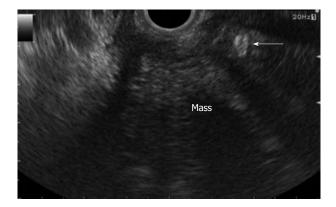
Focal chronic pancreatitis. Endoscopic ultrasonography (EUS) shows a mass with an irregular, inhomogeneous echo pattern, and calcification (arrow) at the head of the pancreas.
